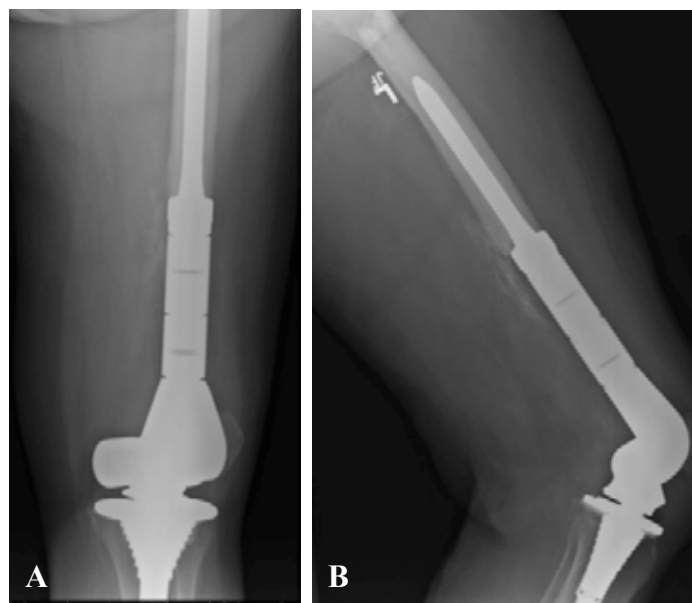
Anteroposterior (A) and lateral (B) radiographs after distal femoral resection and implantation of prosthesis.
